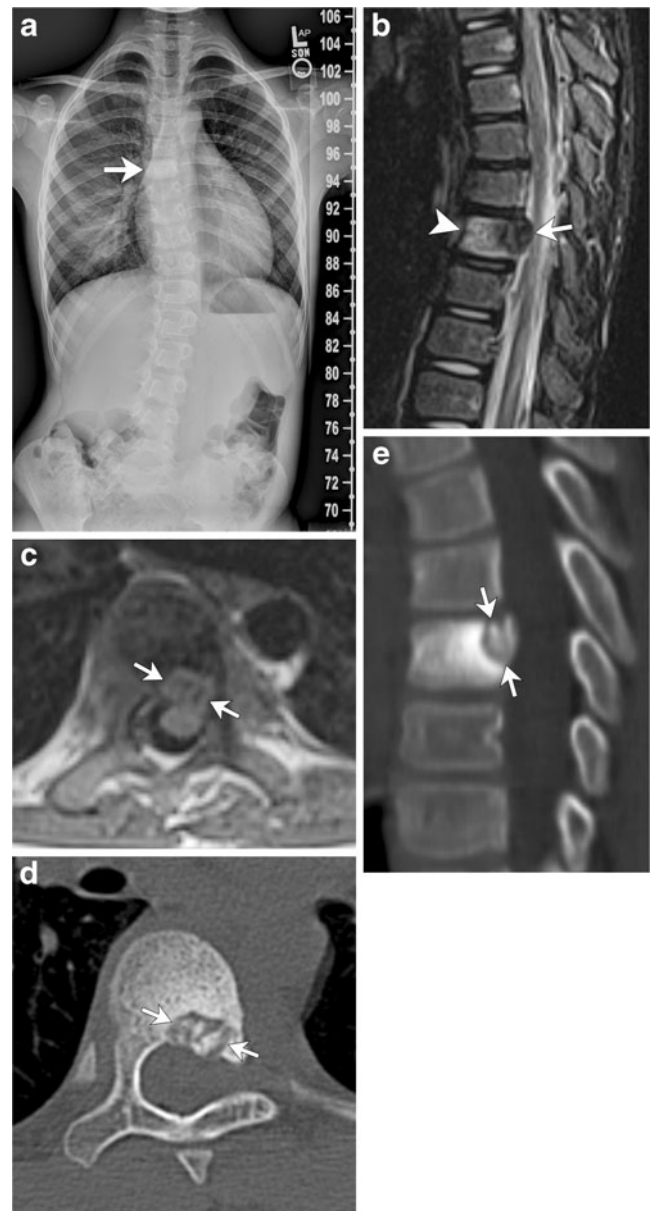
Spinal osteoid osteoma in an 8-year-old boy with scoliosis. a AP radiograph from a scoliosis series shows sclerosis of the T7 vertebral body (arrow) with a mild S-shaped scoliosis. The dominant upper thoracic dextrocurvature is centered at T7. Sagittal T2-weighted (b) and axial T1-weighted (c) MR images demonstrate a T2 hypointense and T1 intermediate signal nidus (arrows) in the left posterior aspect of T7 with bone marrow edema (arrowhead) within the vertebral body. Axial (d) and reformatted sagittal (e) CT images show a radiolucent nidus (arrows) with irregular central calcification and surrounding sclerosis of the T7 vertebral body
